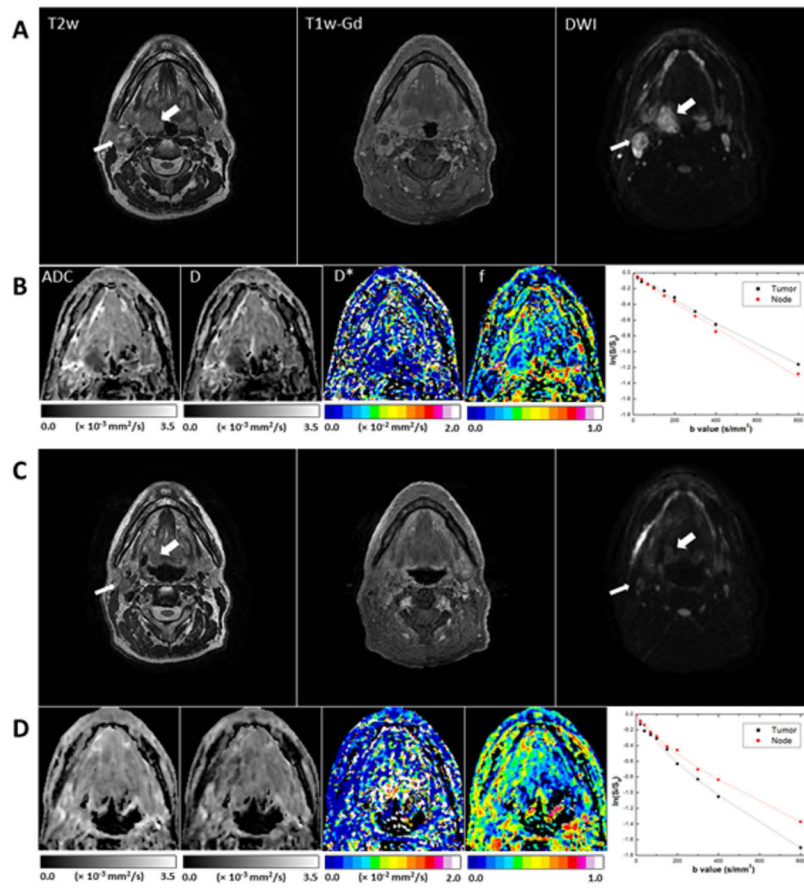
Representative MR images of a tumor (right tonsil; thick arrows) that had a midtreatment CR and a lymph node metastasis (thin arrows) that had a midtreatment PR (patient 5, a 60-year-old man). (A, B) Pretreatment scans; (C, D) midtreatment scans. The T2w, T1w-Gd, and DWI ($b = 800 \text{ mm}^2/\text{s}^2$) images (A, C) were windowed to have similar image contrast, whereas ADC and IVIM parameter maps (B, D) were scaled according to the scale bars shown below the images (the scales used for midtreatment images were the same as those used for pretreatment images). Logarithmic plots of biexponential signal decay in the primary tumor and nodal metastasis are shown on the right in panels B and D.
